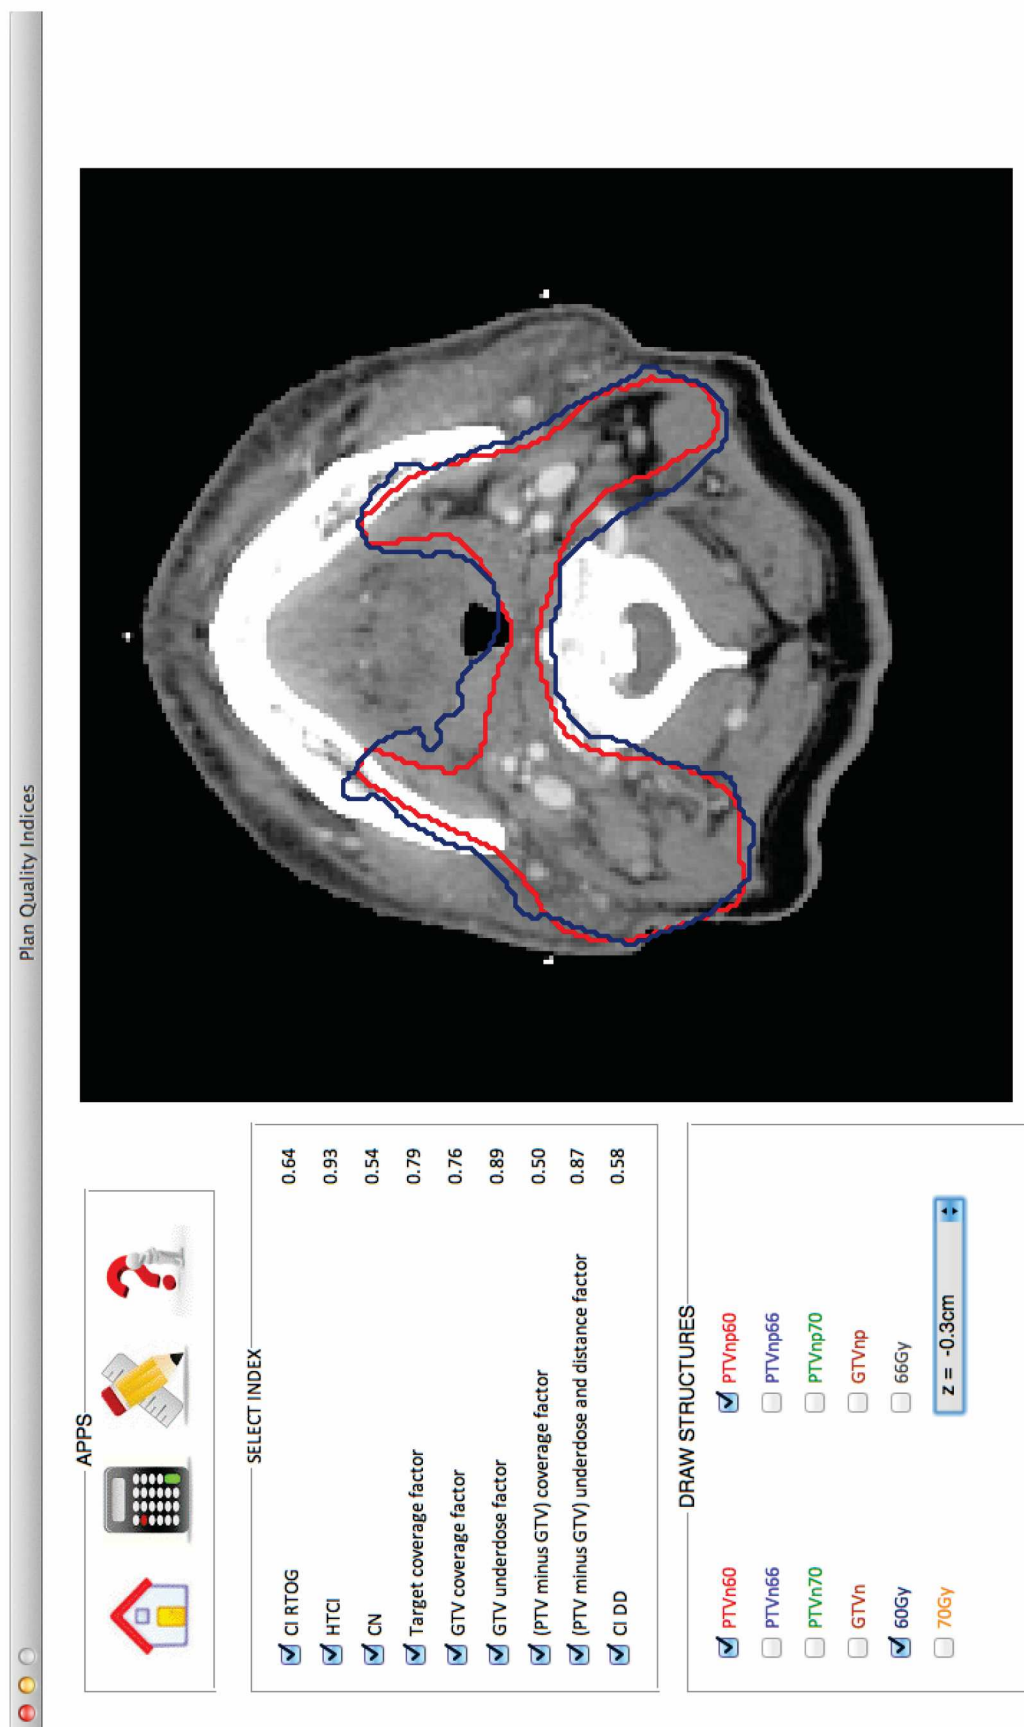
Graphical user interface for calculation of different plan quality indices. The PTV_{n60} and 60Gy isodose line are indicated by red and blue lines, respectively. All PTVs and prescription isodose lines could be shown on every CT slice by selecting their corresponding checkboxes.
